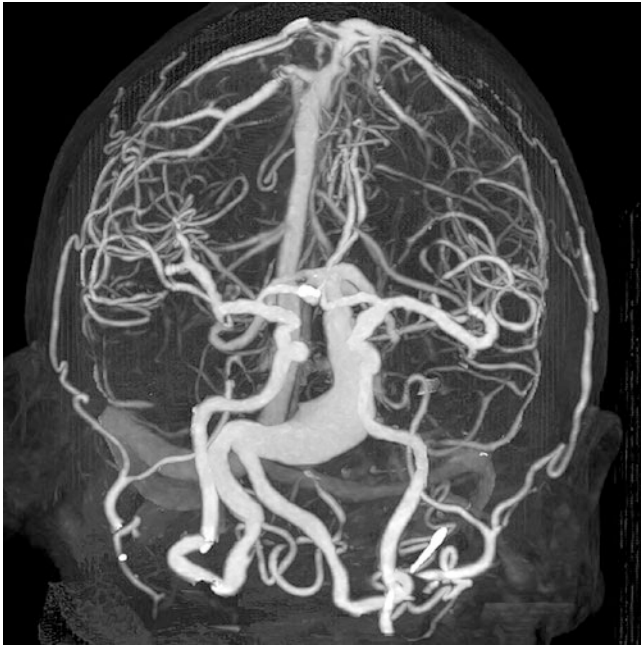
Dolichoectasia. Patient with acute brain stem infarction. CTA shows marked fusiform aneurysmal dilatation of the basilar artery
